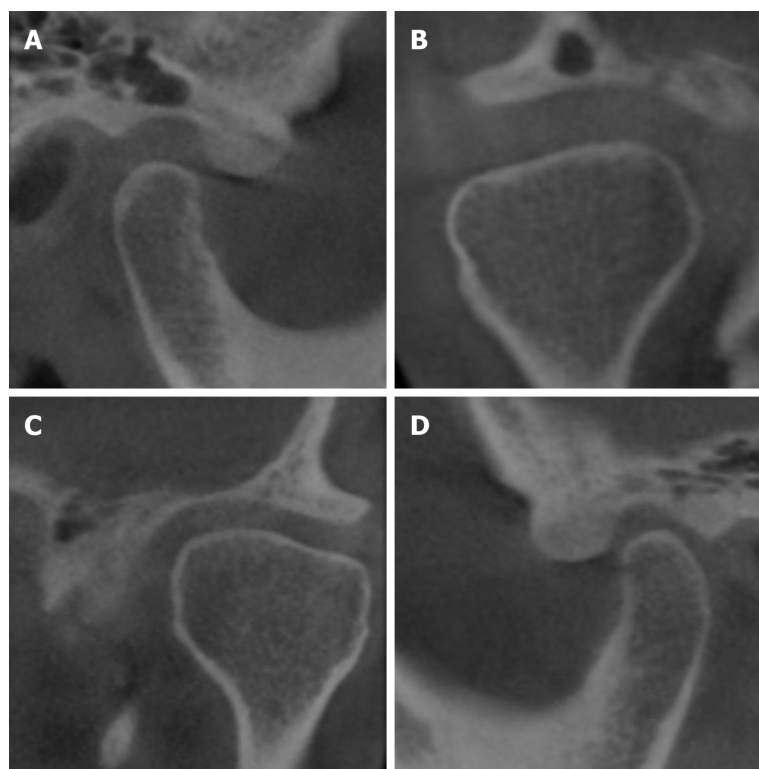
Cone-beam computed tomography examination of the temporomandibular joint. A: Sagittal projection of the right temporomandibular joint (TMJ) showing increased posterior joint space; B: Coronal projection of the right TMJ showing increased medial and lateral joint space; C: Coronal projection of the left TMJ; D: Sagittal projection of the left TMJ.
